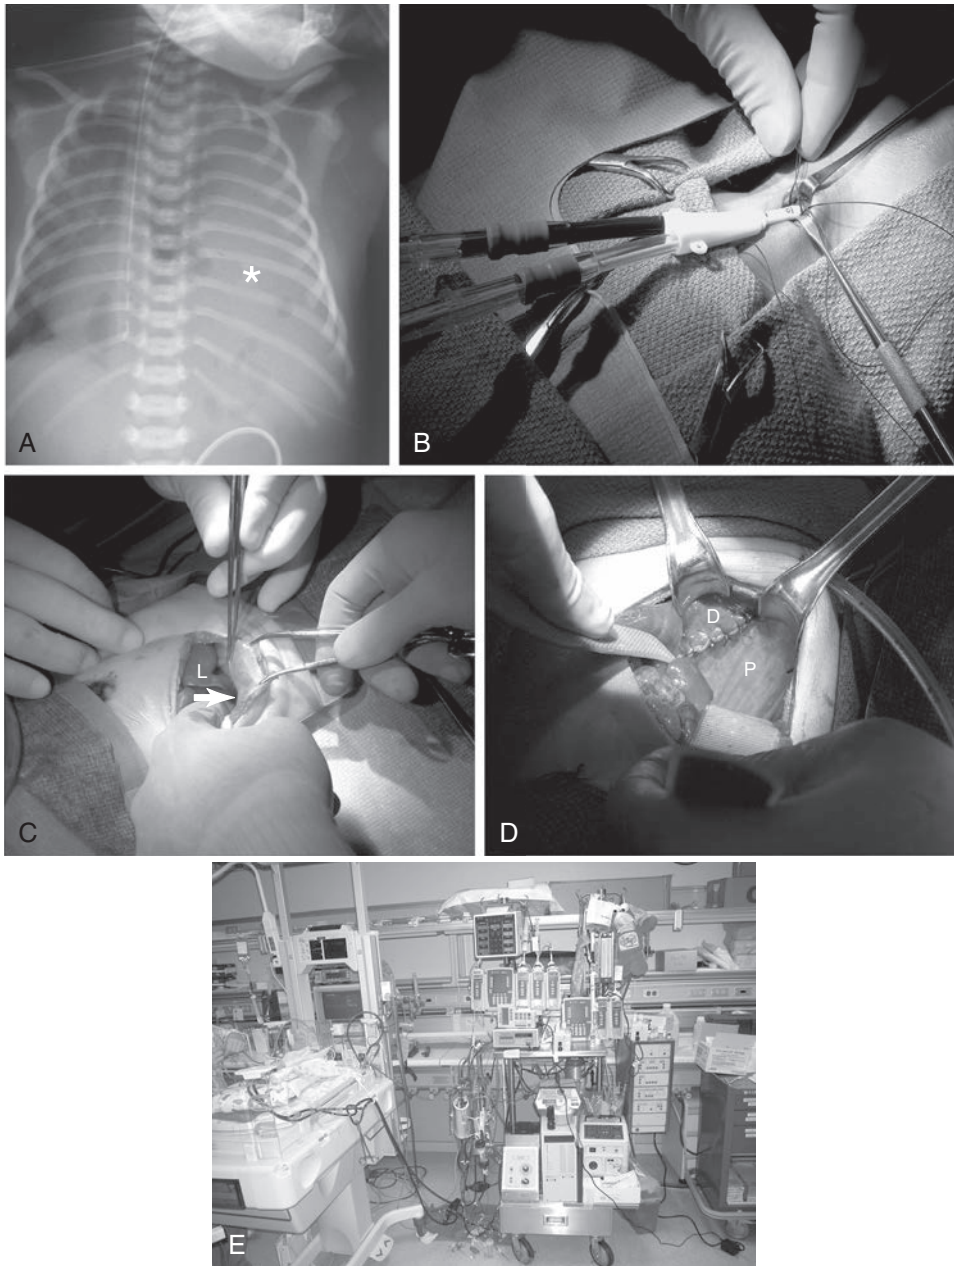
Newborn with left congenital diaphragmatic hernia (CDH), or Bochdalek hernia. A, Chest radiograph shows liver herniation (asterisk) into the left chest. Note displacement of heart and orogastric tube to right and minimally aerated lung on left. B, Dual-lumen venovenous cannulation via right internal jugular vein for extracorporeal life support (ECLS). C, Four days later, baby had stabilized on ECLS, so repair was performed in the neonatal intensive care unit (NICU) on ECLS. Note left lobe of liver (*L*) herniating beneath a diminutive anterior leaflet of the left diaphragm (in forcep). Left lobe of liver is between forcep and surgeon index finger. D, Defect required a biosynthetic patch (*P*; *D*, anterior leaflet of diaphragm). E, Panoramic view of neonatal ECLS equipment, which aids in bedside operative planning.
